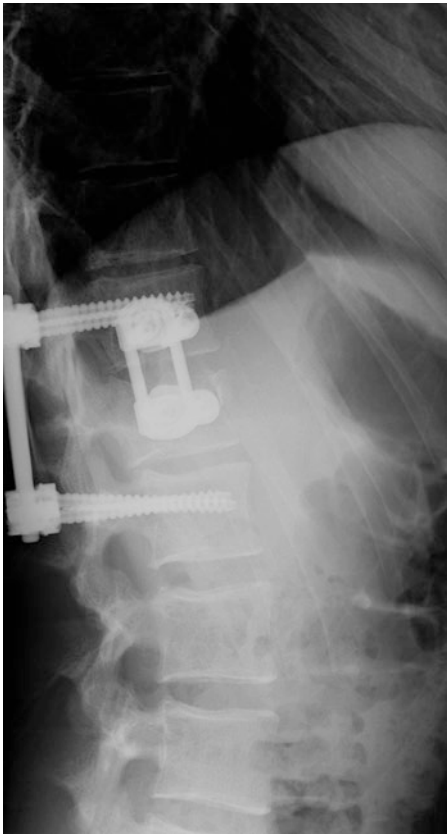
Radiographic image of the same patient after surgery with short-segment posterior fixation Th11–L1 and accomplishment with anterior lumbar corpectomy via a mini-open, extreme lateral, transpossoas approach
